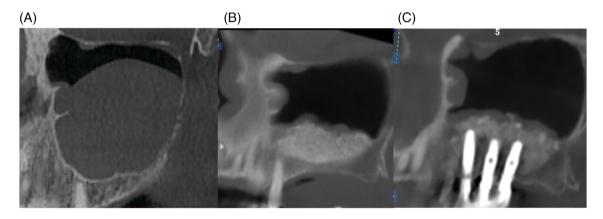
(A) Pre-op CBCT, (B) Post-Op CBCT, (C) 5 years follow up a minimal thickening of the sinus membrane is visible.
